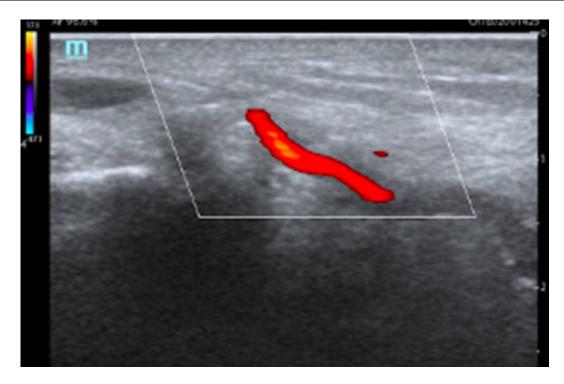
Doppler ultrasound in where it seems a temporal artery wall thickened.
